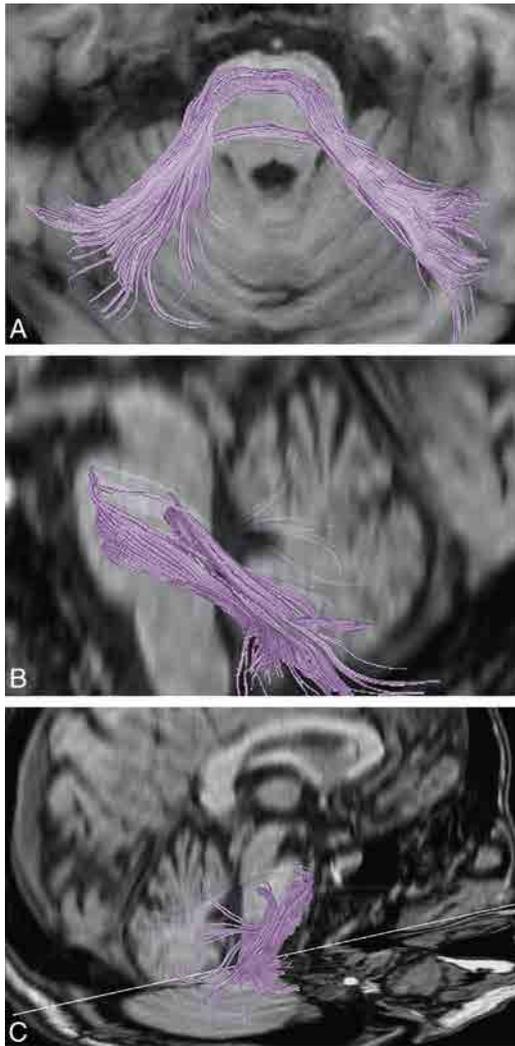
Demonstration of the middle cerebellar peduncles through DTT images on different brain MRI planes.
